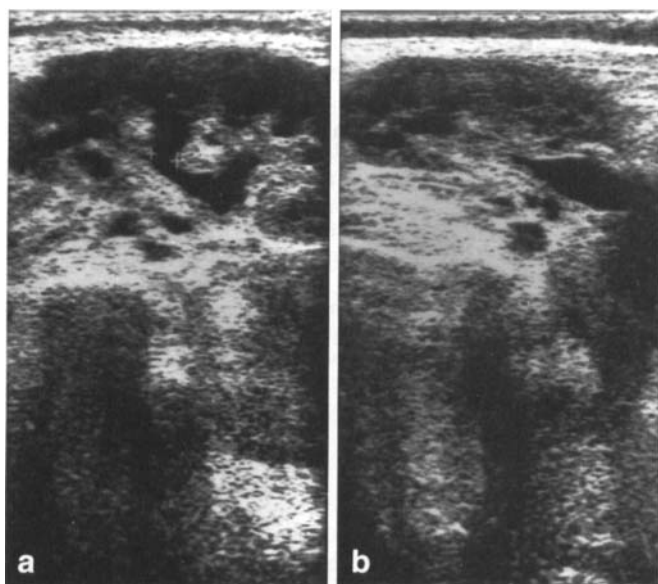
a Longitudinal ultrasound scan of the renal transplant with moderate dilatation of the calyceal system; b ultrasonography of the renal transplant with dilatation of the proximal ureter
